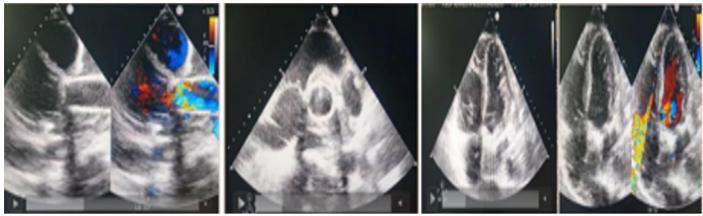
Echocardiography evaluation after Bentall Procedure
